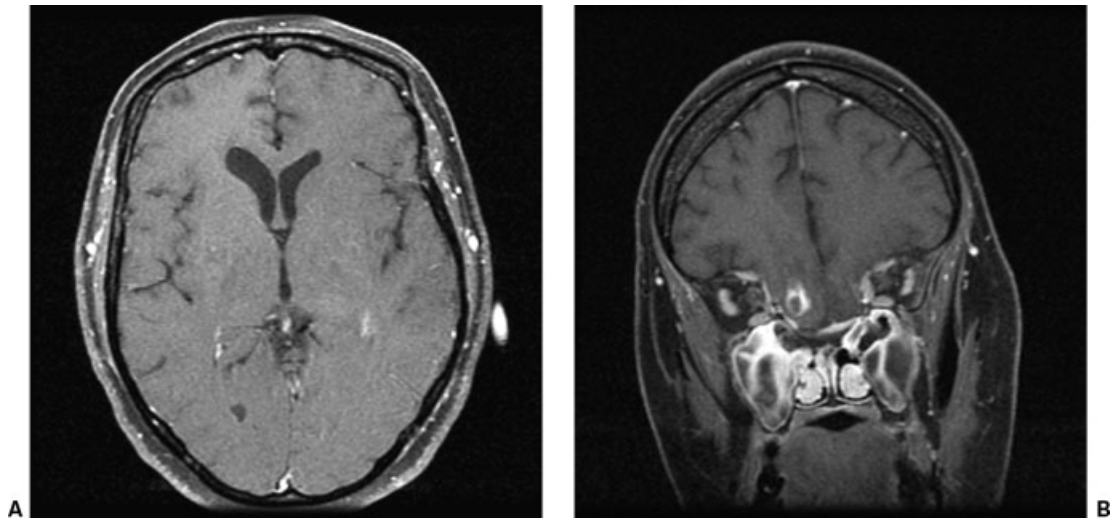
Postoperative (A) axial and (B) coronal T1-weighted MRIs 2 months after endonasal tumor resection show minimal residual enhancement in the surgical bed.
